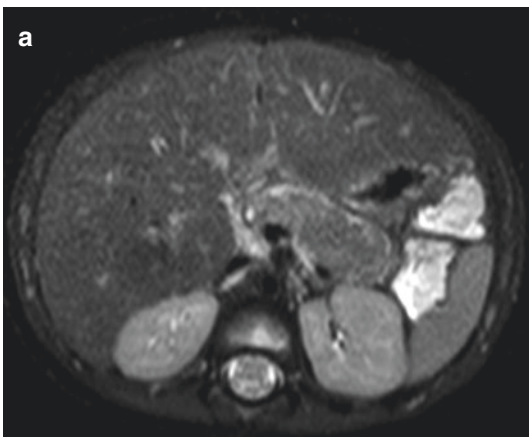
Acute edematous pancreatitis on MR imaging in a 5-year-old child. (a) T2-weighted fat saturation sequence showing a homogenous swollen pancreatic
